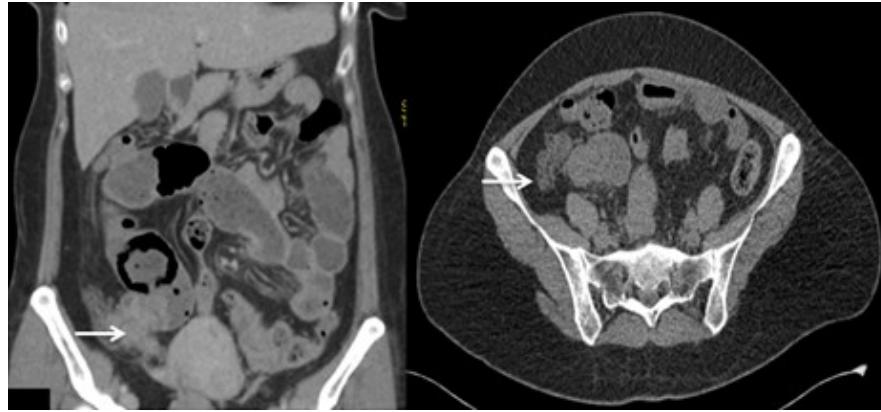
Images of CT scan in coronal view (left) and axial view (right) showing a thickened ileocecal valve and a dilated appendix (arrows).
